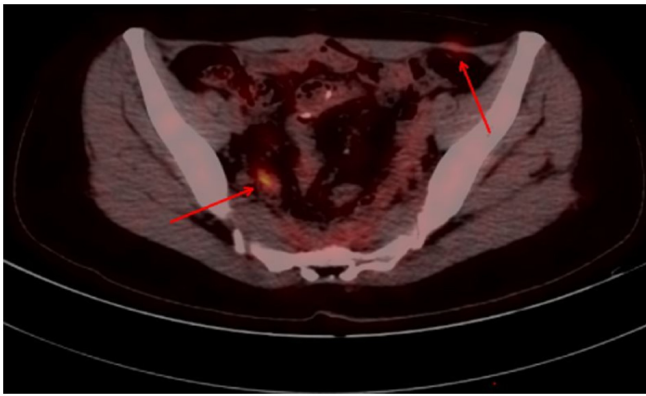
18F-FDG positron emission computerized tomography. Local bowel wall thickening with increased glucose metabolism on the right side of the presacral space (red arrow on the left) and soft tissue nodules with slightly increased glucose metabolism on the left side of the aponurosis area of the musculus obliquus externus abdominis (red arrow on the right).
